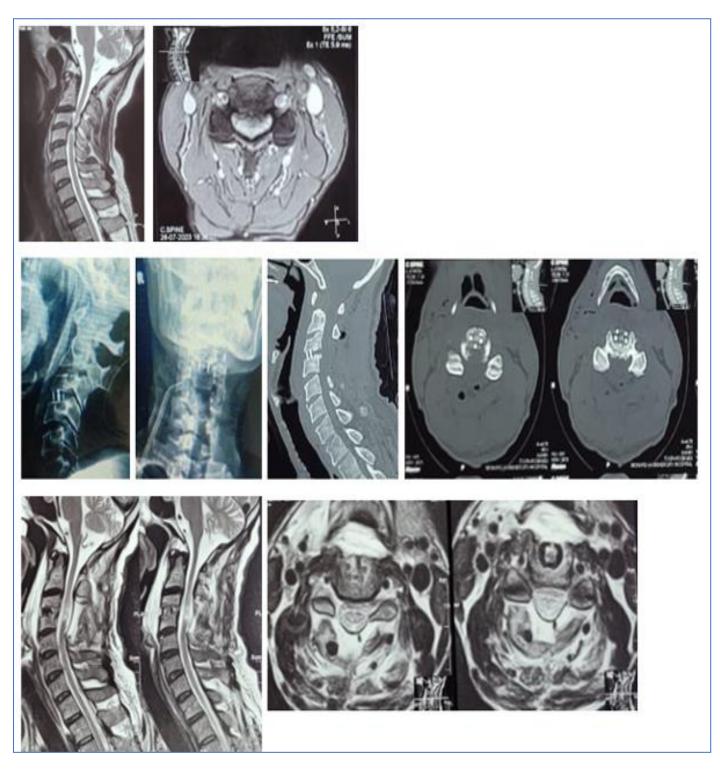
Male patient, 52 y old presented with CSM. Preop VAS score of axial pain was 5. The preop JOA score was 8. MRI cx sp sagittal and axial T2 (a and b) revealed C3-4 CDP causing anterior compression and buckling of the ligamentum flavum causing posterior compression at the same level. The spinal cord showed severe cord compression and contusion. ACDF at C3-4 level with cage was done followed by PCL at the same level in the same sitting. (C & D) postop X Ray cx sp A-P & Lat views, (f.) postop CT cx sp, (g. and h.) postop MRI cx sp; sagittal and axial T2; revealed C 3-4 ACDF with cage together with C 3,4 posterior cervical laminectomy with good decompression of the cord. Postoperatively, VAS score of the axial pain was improved to 2 and JOA score was improved to 14.
